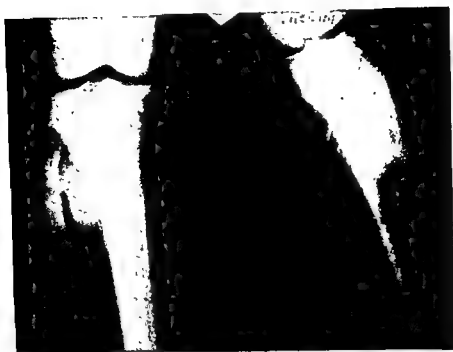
Roentgenogram of a preossifying variant of sclerosing osteogenic sarcoma arising on the lateral aspect of the tibia. The tumor mass is seen arising subperiosteally, causing a dense extracortical shadow. In the lateral view a definite sunray appearance of the soft part shadow is seen. The cortex and marrow cavity beneath it are invaded and sclerosed.
